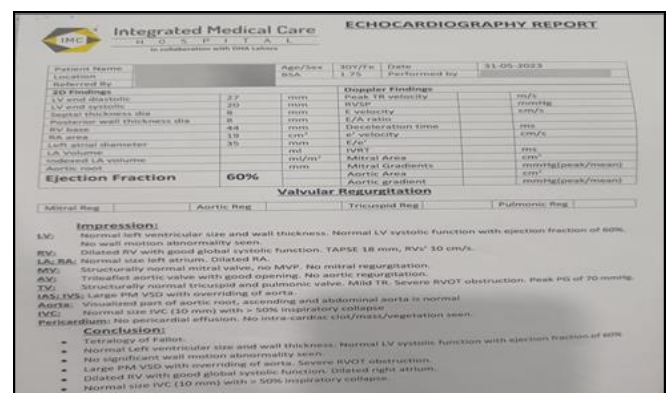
Echocardiography Findings
